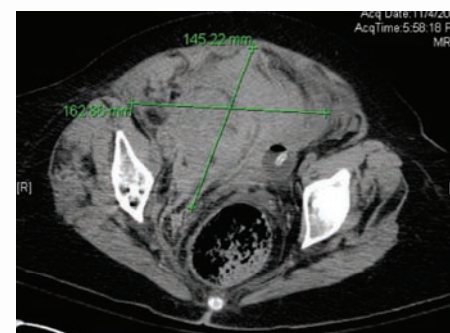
CT scan of the abdomen and pelvis of the patient whose femoral angiogram is shown in Figure 1, showing a large intraperitoneal and retroperitoneal hemorrhage within the pelvis, displacing the bowel and bladder toward the left side of the abdomen.
